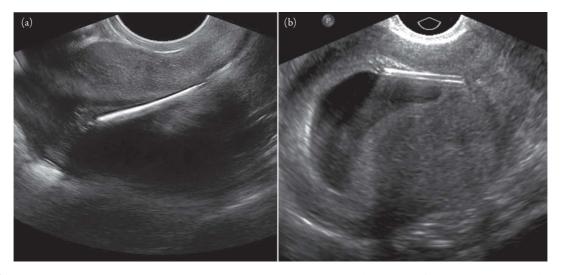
(a) Correctly situated intrauterine device on transvaginal ultrasound. Note that the axis of the IUD is inline with the endometrium. Image courtesy of Dasia Esener, MD, Department of Emergency Medicine, Kaiser Permanente San Diego Medical Center, San Diego, CA. (b) Displaced IUD with intrauterine pregnancy (IUP) on transvaginal ultrasound. This low-lying IUD is seen as an echogenic double-linear band with some ringdown artifact. The IUP is just deep and to the left or fundal to the IUD. Note that the IUD axis is not inline with the endometrium. Image courtesy of Anokh Pahwa, MD, and Shaden Mohammad, MD, Department of Radiology, Olive View–UCLA Medical Center, Los Angeles, CA.
